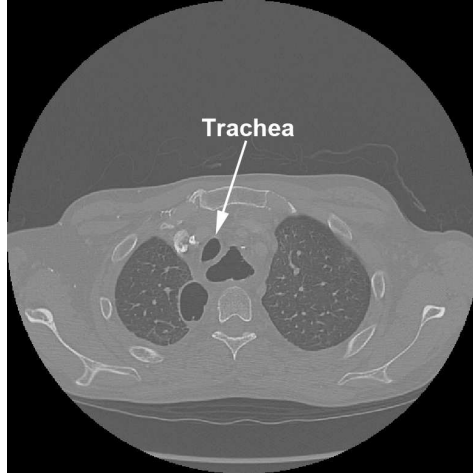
A situation where other structures may mislead the detection of the trachea in an axial slice of the CT scan.
